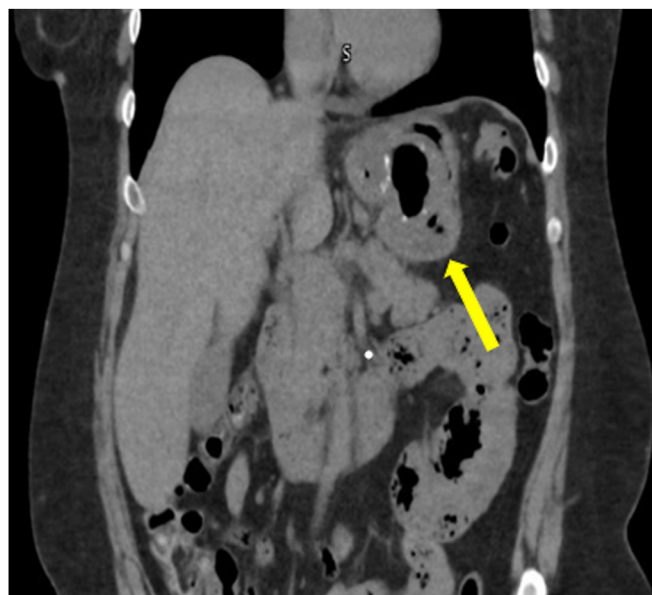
CT scan showing a contained leak along the posterior-medial aspect of the gastric sleeve with mixed gas and fluid collection seen (tip of yellow arrow).
